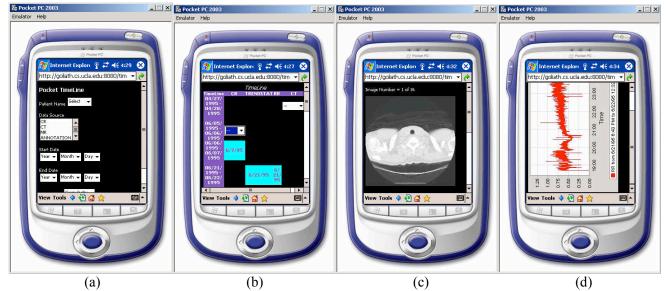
(a) The mobile physician selects the patient, the data sources, and the time span of interest from the main menu. (b) Given the inputs provided in the main menu, the system creates a vertical timeline of patient records (e.g., CR, trend statistics, RR intervals, and CT records). One of the capabilities of the Pocket TimeLine is to be able to view images, shown in (c), and to view graphs of data generated by the LifeShirt, shown in (d) by selecting the appropriate records from the timeline.
